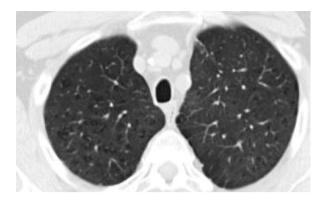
HRCT of the lungs: panlobular pulmonary emphysema
